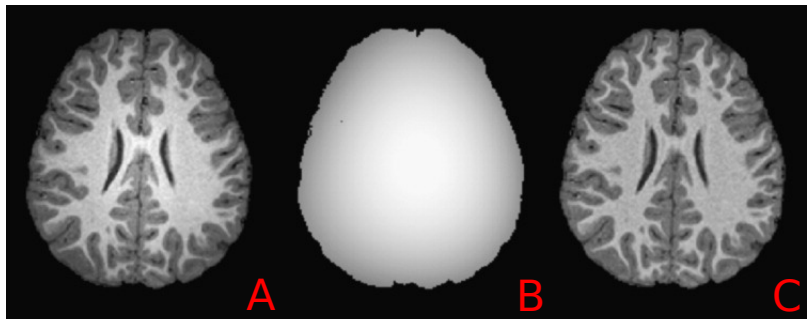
A- Brain MR image presenting high intensity inhomogeneities; B- Estimated bias field; C- Corrected MR image for intensity inhomogeneities,[Ji et al., 2011].
